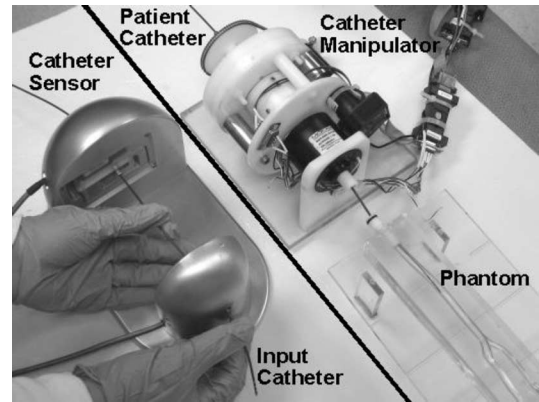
Remote catheter navigation system: The interventionalist can pull, push or twist the input catheter inside the CS. Motion measured by the CS is then replicated with the patient catheter using the remotely placed catheter manipulator. Image feedback is provided by a standard fluoroscopic X-ray system (not shown).
